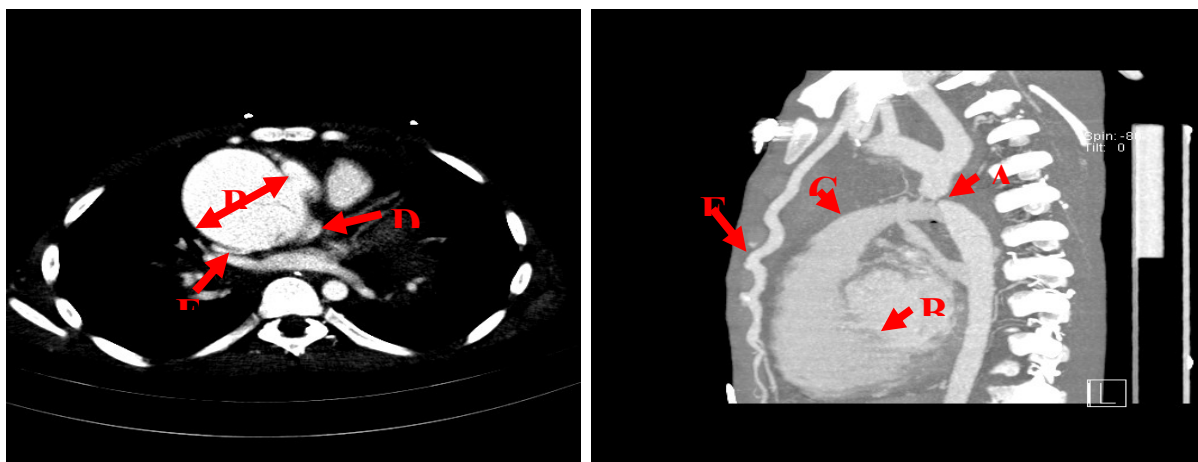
CT angiography of the mediastinum showing a postductal aortic coarctation with a 4-mm stenotic segment (A) - Significant dilation in ascending Aorta (67×82 mm) beginning from aortic root (56×63 mm) (B) and extending to the arch (26×15 mm) (C) - Type A aortic dissection with a thin flap in aortic root extending to mid ascending aorta; the flap is also extended to the posterior sinotubular junction (D) and RCA (E) - Marked vascular collateral formation and dilation of internal mammary artery (5 mm) (F).
